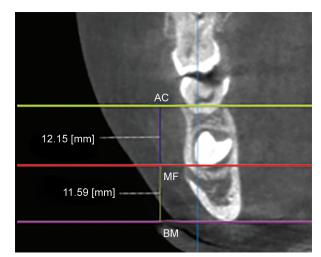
Assessment of MeF using CBCT: location of the MeF. Landmarks used in the present study. The superior margin of the MeF, the AC, the BM
